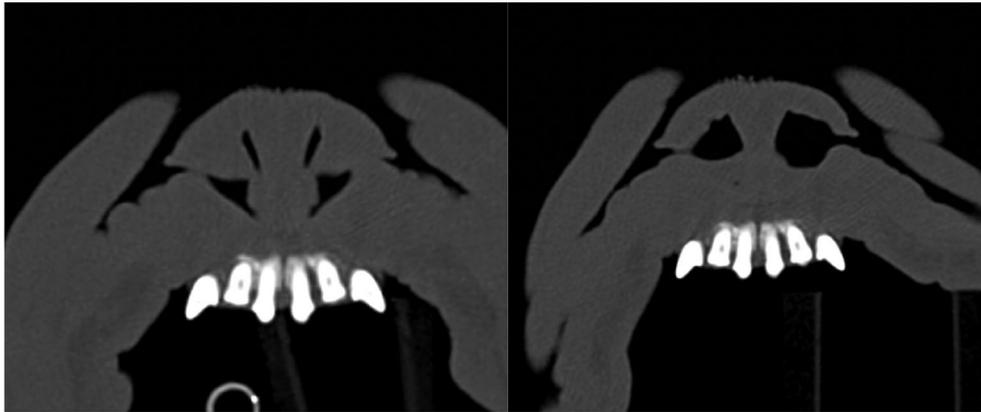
Transverse section of a French Bulldog head CT of the nares at point 1 preoperatively (left) and postoperatively (right).
